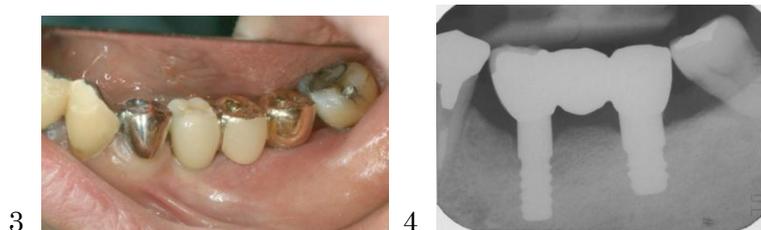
4: 4MM and 5SS were installed (10.22.2004) followed by bridge placement (01.29.2005). Image of the oral cavity, and a radiograph shown at the time of gaining occlusal support on the left mandible.
